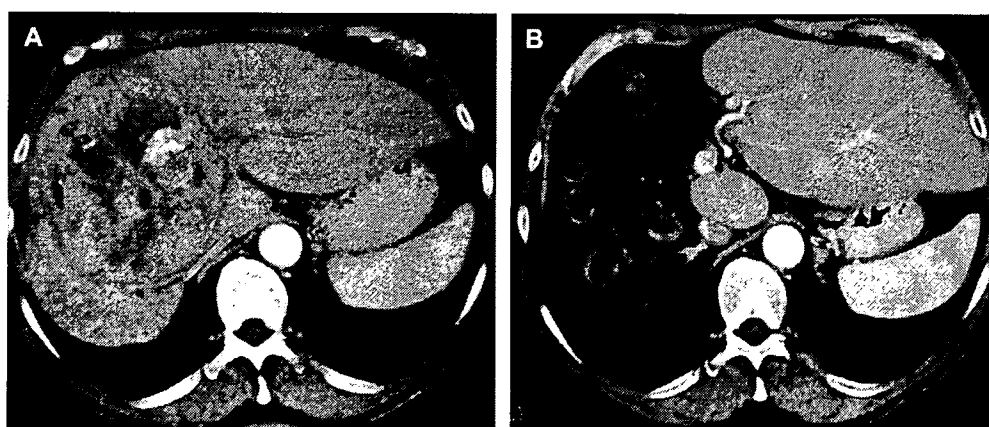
Contrast-enhanced computed tomography (CT) findings of a 66-year-old man with multiple hepatocellular carcinomas (HCCs). (A) CT before reduction hepatectomy demonstrates an HCC measuring 14 cm with many intrahepatic metastases throughout both lobes. The preoperative alpha-fetoprotein level was 6717 ng/ml, and no tumour thrombus was observed in the hepatic or portal veins. Liver function was preserved (ICG R₁₅ = 8.7%). The patient underwent reductive right tri-segmentectomy. (B) CT 4 years after reduction hepatectomy demonstrates small tumours well controlled by 10 successive transcatheter arterial chemoembolizations.
